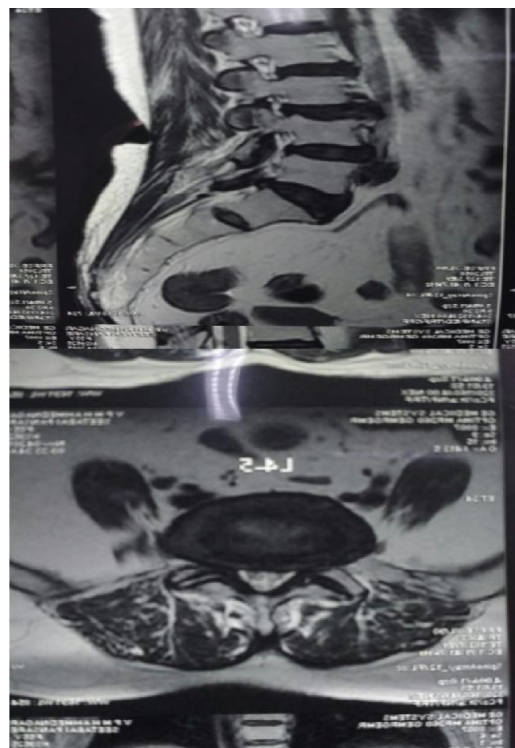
MRI images of PIVD L4-L5, L5-S1
